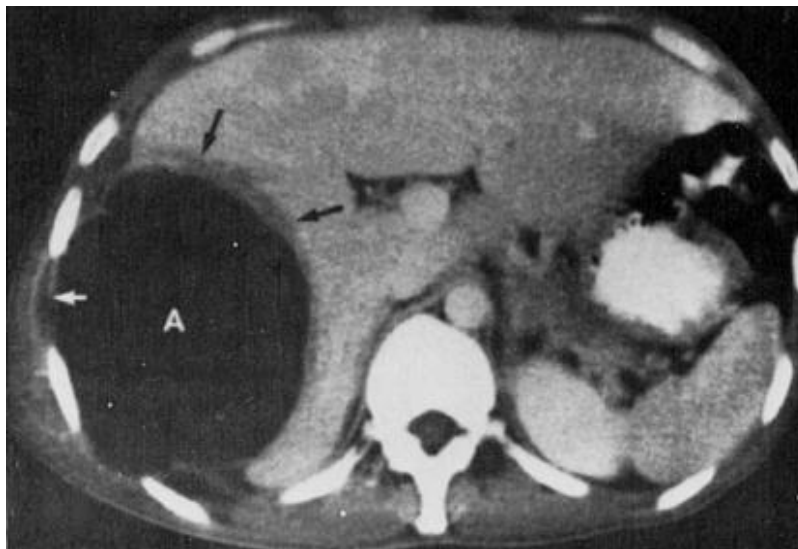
Contrast-enhanced CT scan of amebic abscess (A). The lesion is peripherally located and round. Rim is nonenhancing but shows peripheral edema (black arrows). Note the extension into the intercostal space (white arrows).
